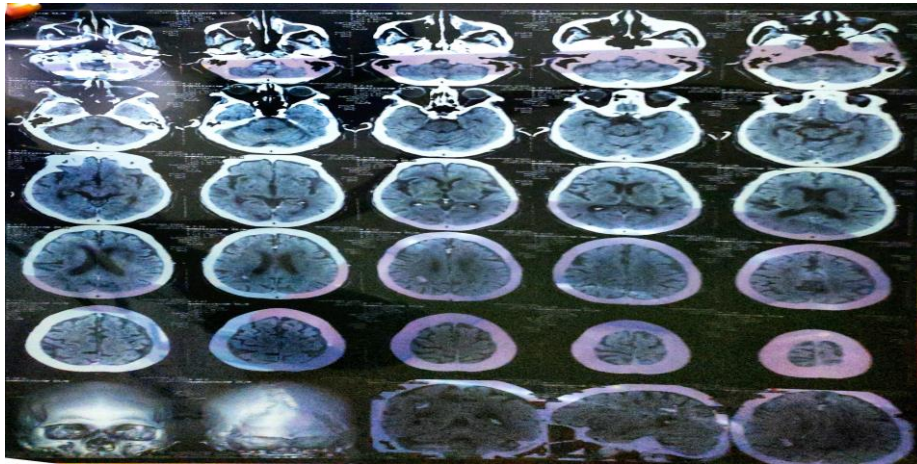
Axial View Of MRI
